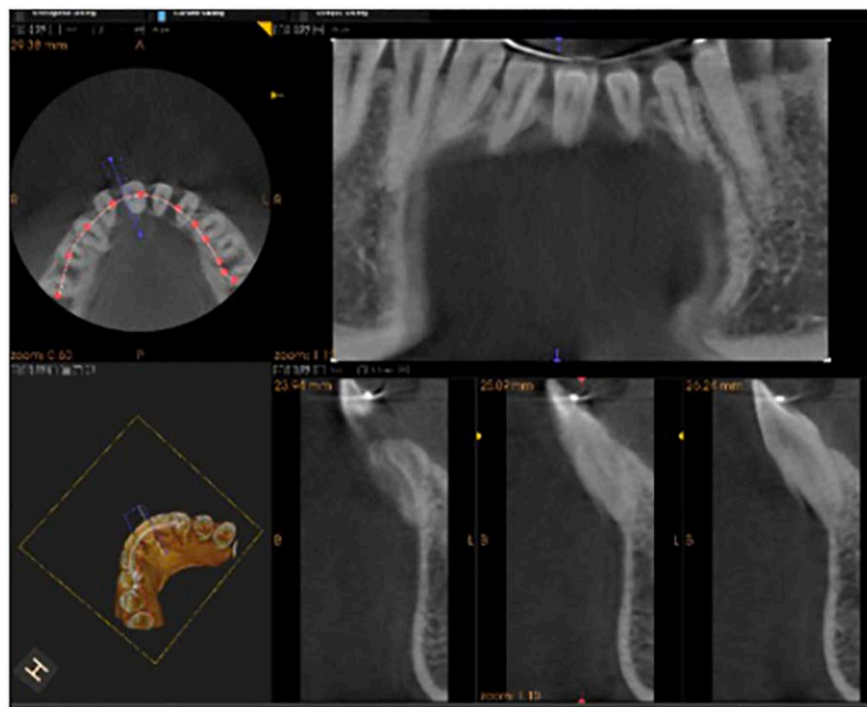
Evaluation of bone support of the lower incisors using a localized CBCT in KODAK™ software.
